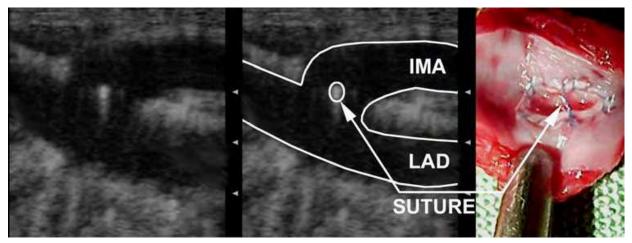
Longitudinal ultrasound image of an incorrect anastomosis with suture cross-over with corresponding macroscopic view of the anastomotic orifice after incision of the posterior wall of the LAD. Arrow indicates overcrossing suture. (Reprinted with permission from Budde R. et al, Robot-assisted 13 MHz epicardial ultrasound for endoscopic quality assessment of coronary anastomoses. Interactive Cardiovascular and Thoracic Surgery 2004;3:616-20)
